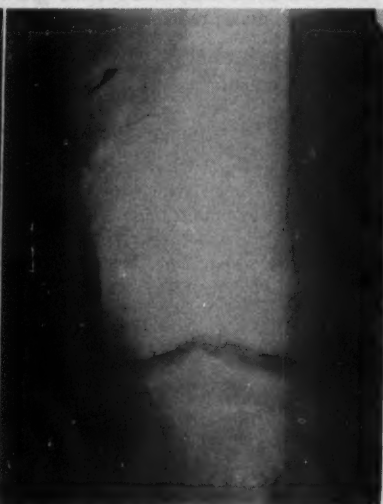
Roentgenogram taken August 15, 1950, shows the sarcoma in same area as previously noted osteolysis.
